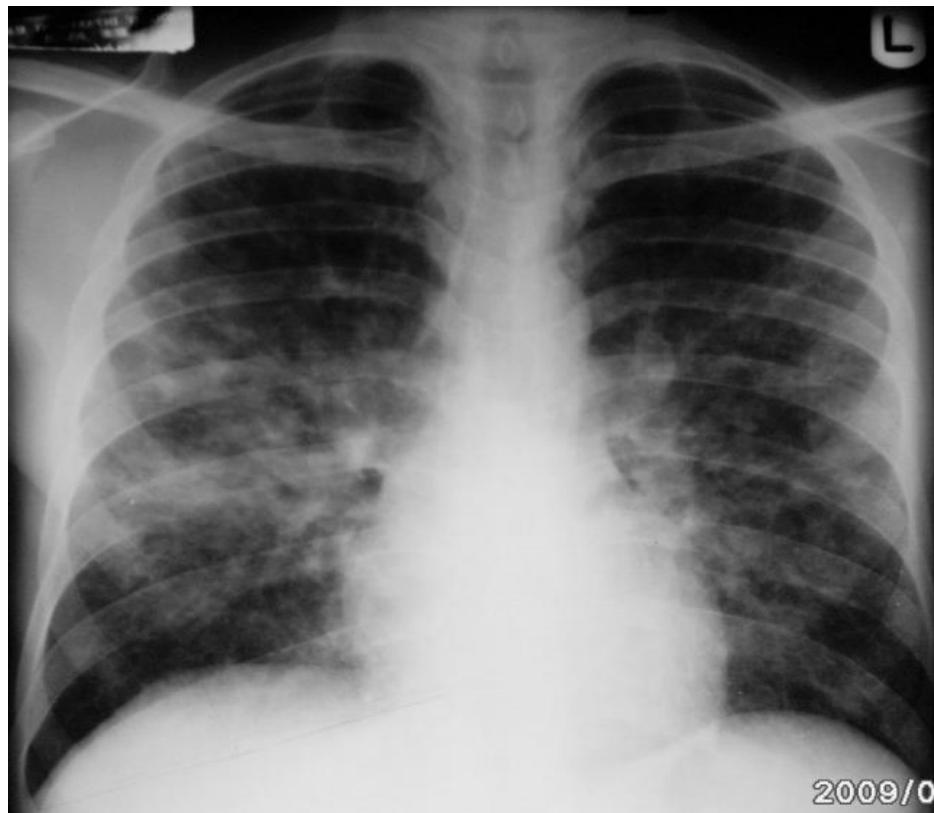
Chest radiograph showing bilateral nodular consolidations in a HIV seropositive patient due to tuberculous bronchopneumonia.
